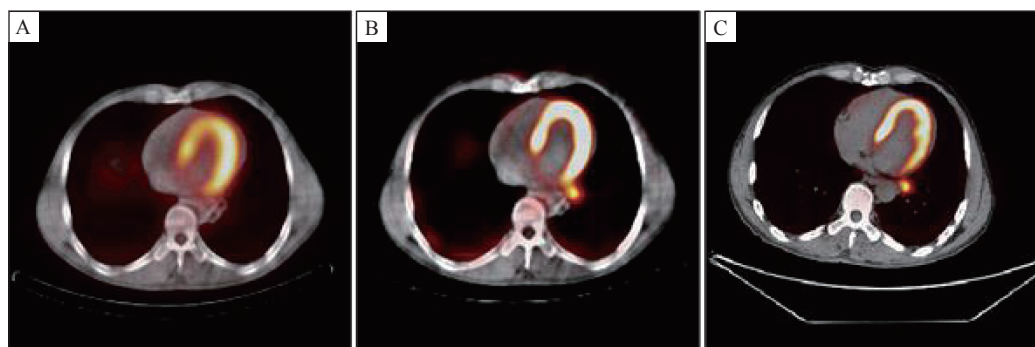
A representative patient with a metastatic mediastinal lymph node as esophagus cancer near myocardium. A: conventional Co-SPECT; B: quantitative Co-SPECT; C: PET.
